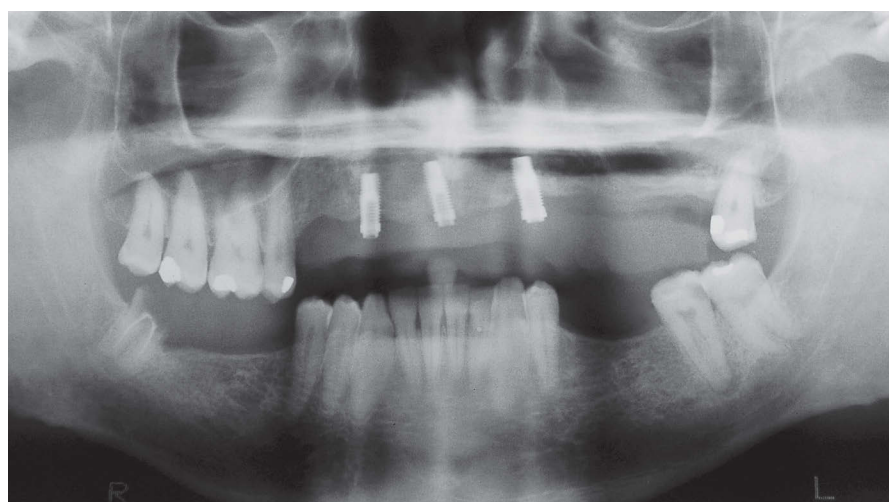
Postoperative radiograph after 6 months showing implants placed in the anterior maxilla with no trace of the implant which had accidentally been displaced into the maxillary sinus.
